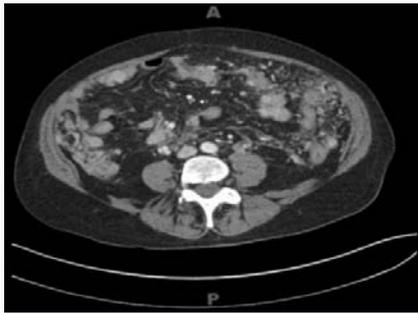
CT scan shows peritoneal deposits along with small intestine.
